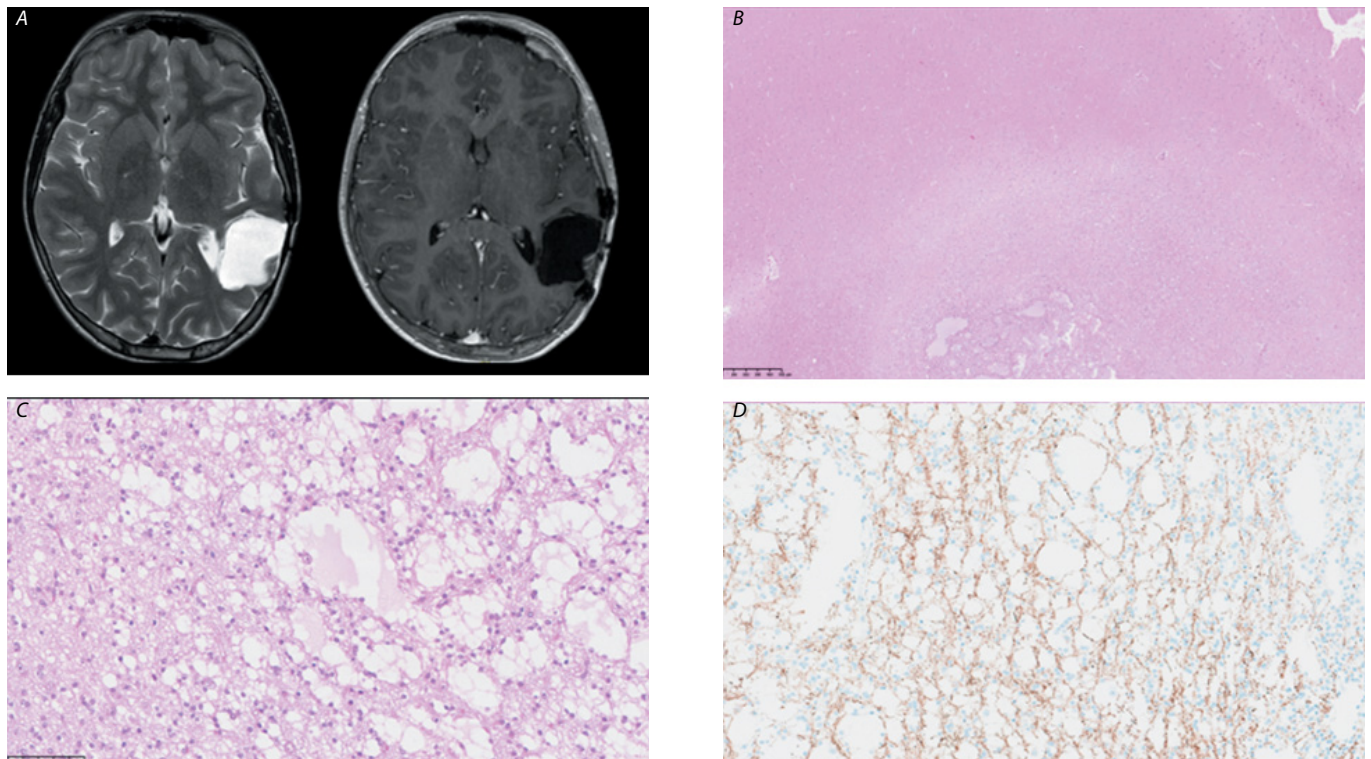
Postoperative MRI and morphological findings of patient G.
